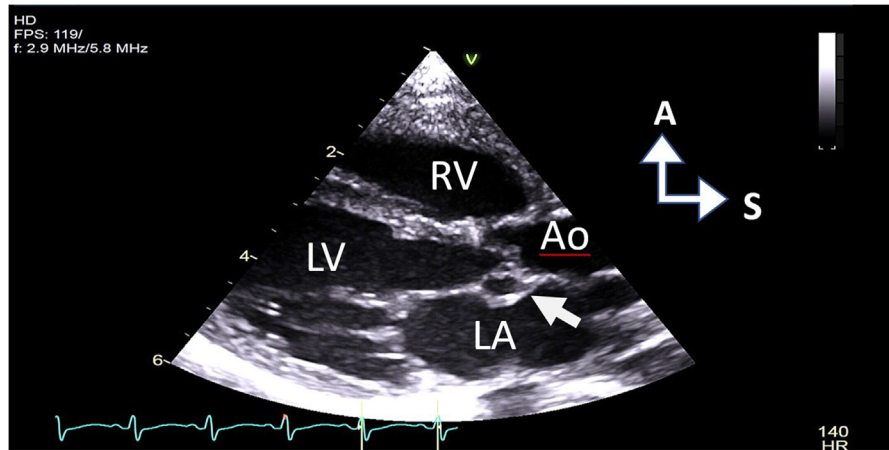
Parasternal long-axis view demonstrates abnormal left posterior leaflet (arrow) entrapping left sinus of Valsalva. A, Anterior; Ao, aortic valve; LA, left atrium; LV, left ventricle; RV, right ventricle; S, superior.
